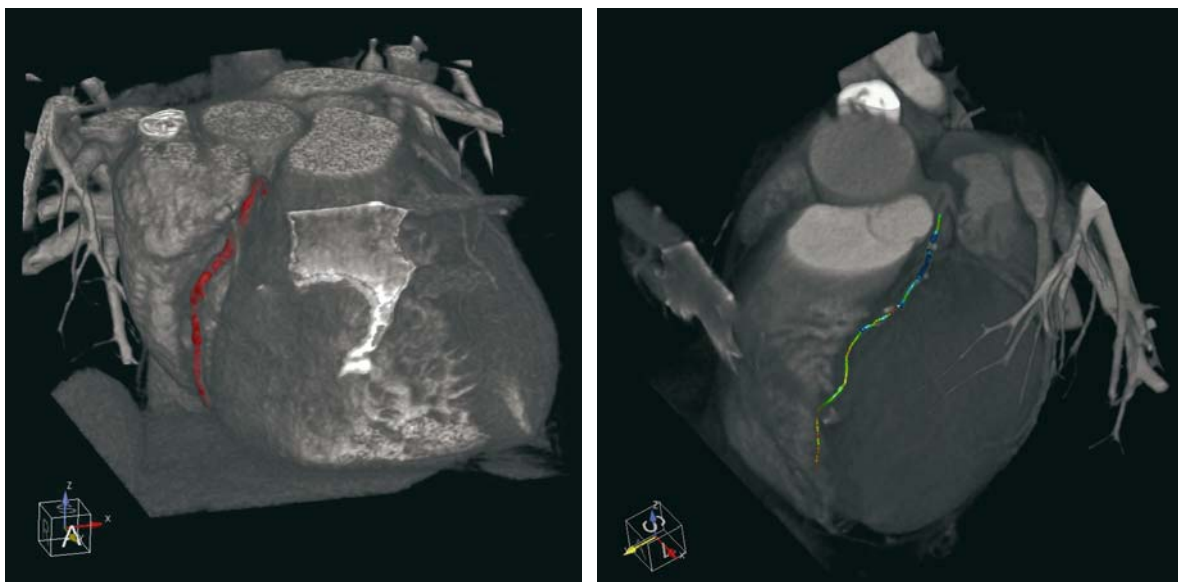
Tracking-based segmentation of coronary arteries in cardiac CT data sets (left: vessel boundary, right: colour-coded centreline corresponding to the vessel's diameter)
